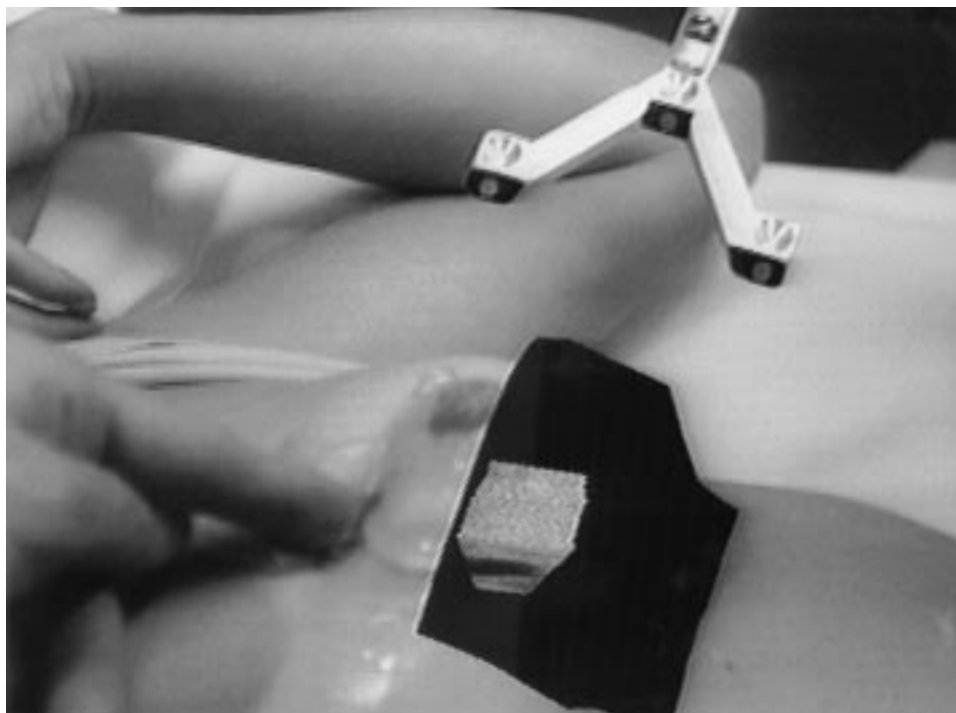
View presented inside the user's head-mounted display in real-time during the experiment depicted in Figure 3. The synthetic opening covering the bottom half of the breast contains a volume of 2D ultrasound slices, showing a cross-section through a liquid-filled cyst inside the breast. The physician's left index finger points to the location of the cyst as she perceives it via tactile feedback, verifying correct enhanced imaging registration.
